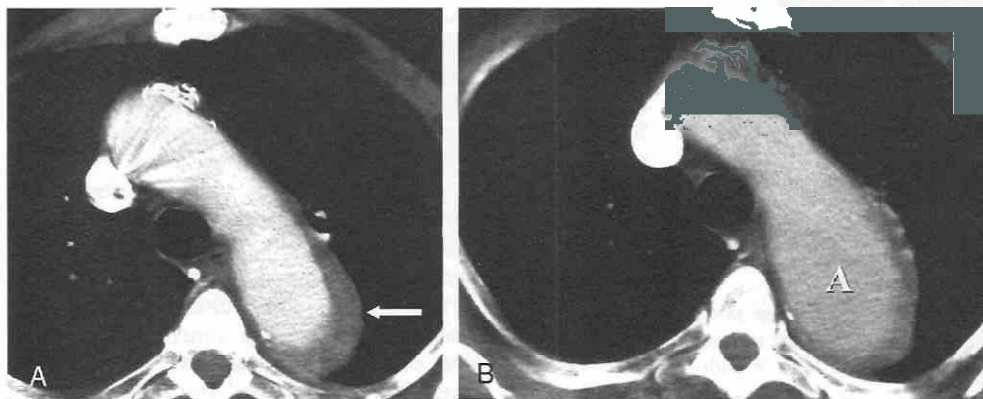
A, Axial CT scan in a patient with acute back pain. There is a large amount of high-attenuation periaortic soft tissue (arrow), a feature consistent with intramural hematoma. B, Axial CT scan taken 2 months later shows a rapid increase in the diameter of the descending aorta (A).
